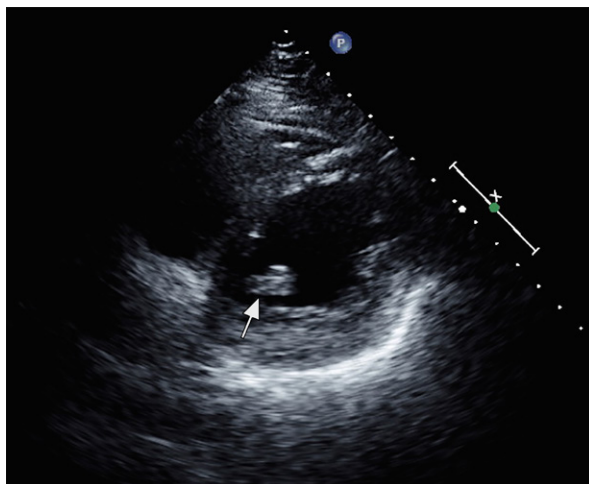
Transthoracic echocardiogram shows a mobile thrombus (arrow) within the right atrium.
